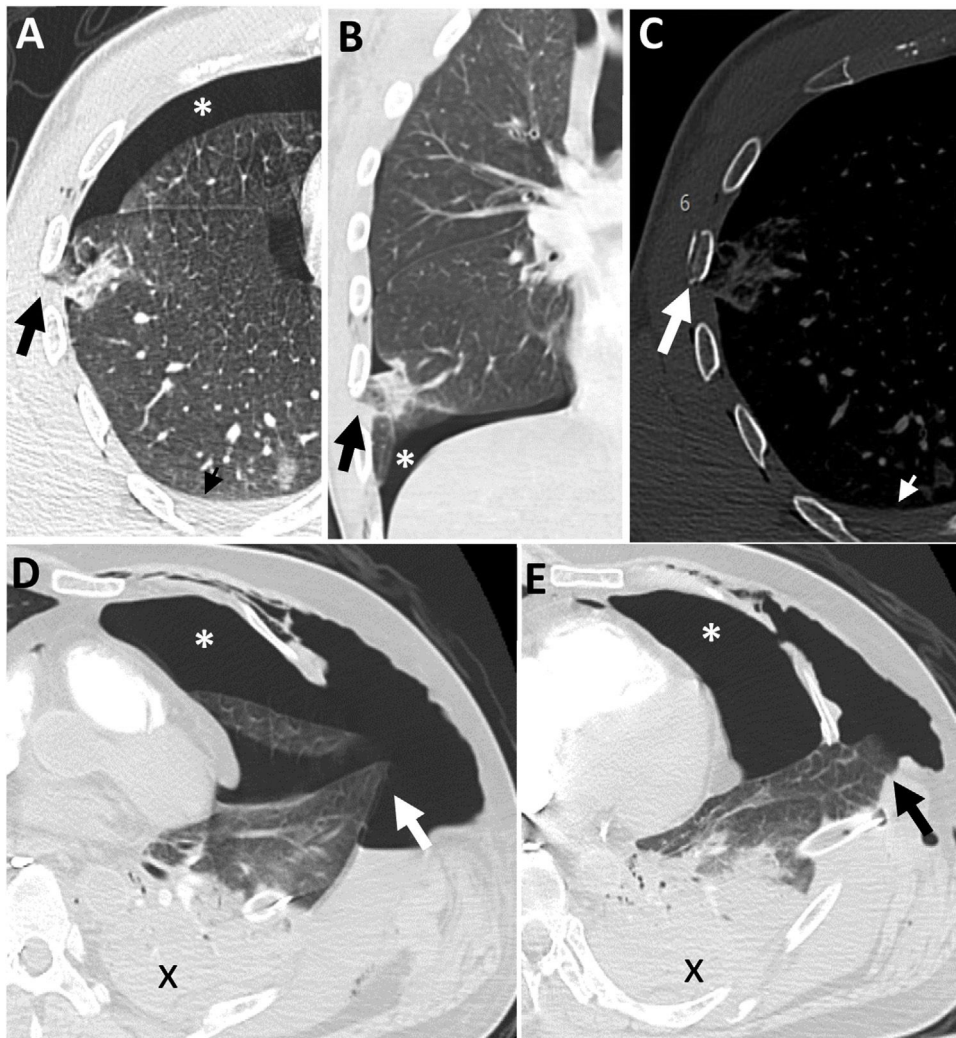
30-year-old male involved in a motorcycle accident (A-C). Chest CT images (axial [A] and coronal [B] in lung window, axial [C] in bone window) showing a small pulmonary hernia (black arrows), rib fracture (white arrow), pneumothorax (asterisks) and minimal pleural effusion (arrowheads). Coronal reconstructions, rib fractures or a history of a chest drainage tube are very useful diagnostic clues for its detection. 40-year-old male who fell from the ninth floor (D and E). Axial chest CT images (lung window) showing a large left pulmonary hernia (arrows), pneumothorax (asterisks) and lower lobe contusion/atelectasis (x).
